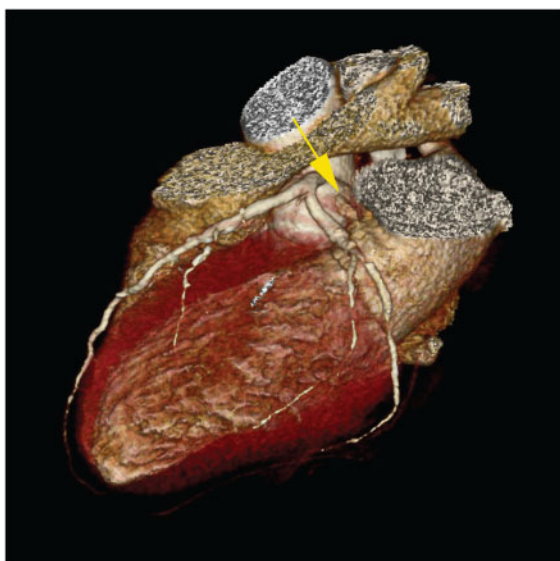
Computed tomography imaging of the heart showing three-dimensional volume rendered imaging sequence demonstrating rudimentary left atrial appendage (yellow arrow). Limited visibility of left atrial appendage in both imaging modalities emphasizes the importance of thorough multimodality assessment of left atrial appendage anatomy.
